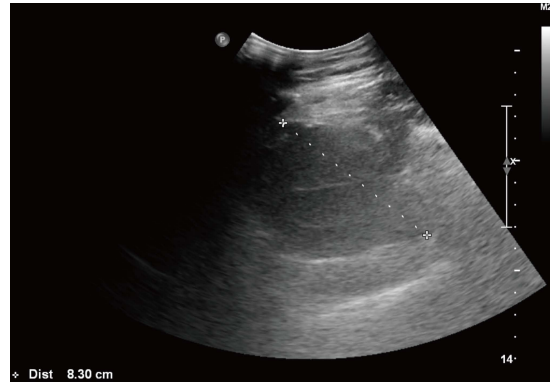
Ultrasound of the thigh showing an intramuscular hematoma of the anterior compartment.
